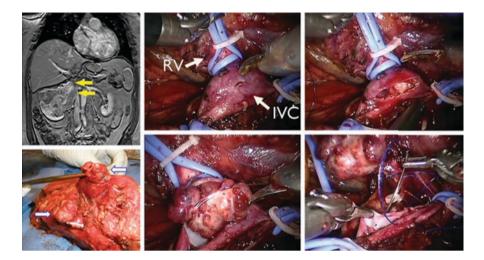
Patient with two renal veins each with caval tumor thrombus, as seen on magnetic resonance imaging (upper left), after extraction (lower left) and intraoperatively with modified Rommel tourniquets for cross-clamping of the inferior vena cava (IVC) and lightly applied to prevent back bleeding from the right renal vein (RV) to open and deliver lower thrombus in a bloodless filed (right)
